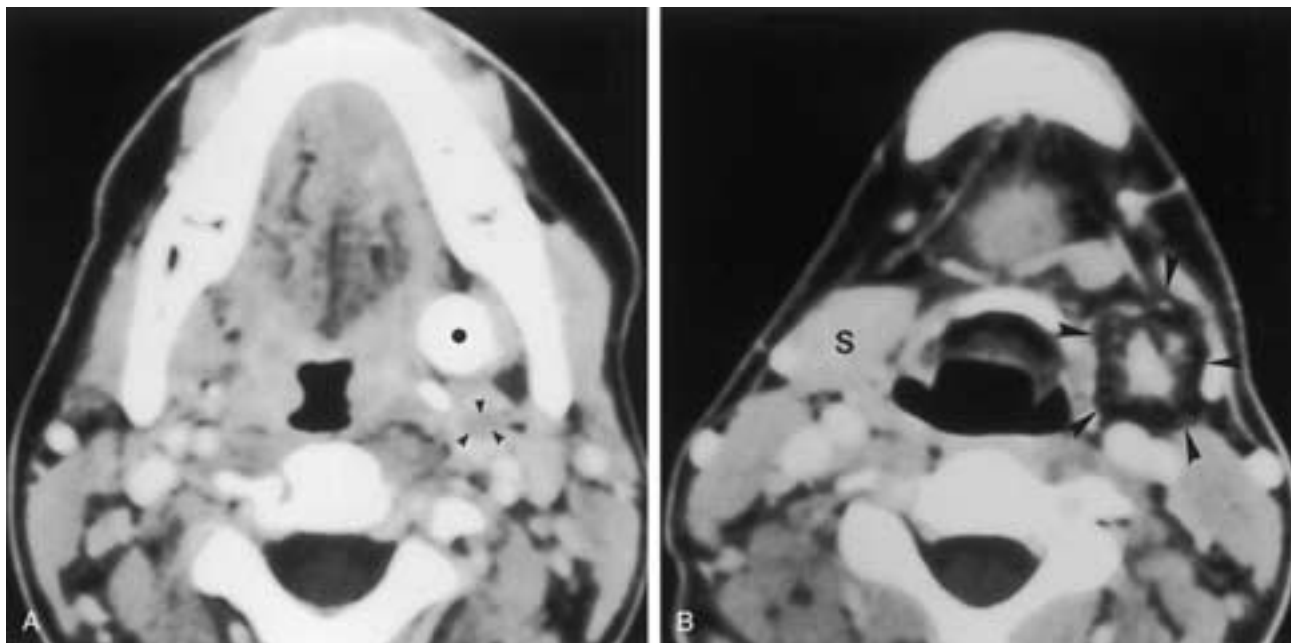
Submandibular gland duct calculus with submandibular gland abscess. Axial CT scan (A) with contrast enhancement demonstrates a large calculus (*black dot*) along the course of the submandibular gland duct. The most superior extent of the resulting abscess involving the left submandibular gland may be identified on this image (*arrowheads*). B, Axial CT scan with contrast enhancement at a lower level reveals a normal right submandibular gland (S). An extensive abscess involves the majority of the left submandibular gland (*arrowheads*).
